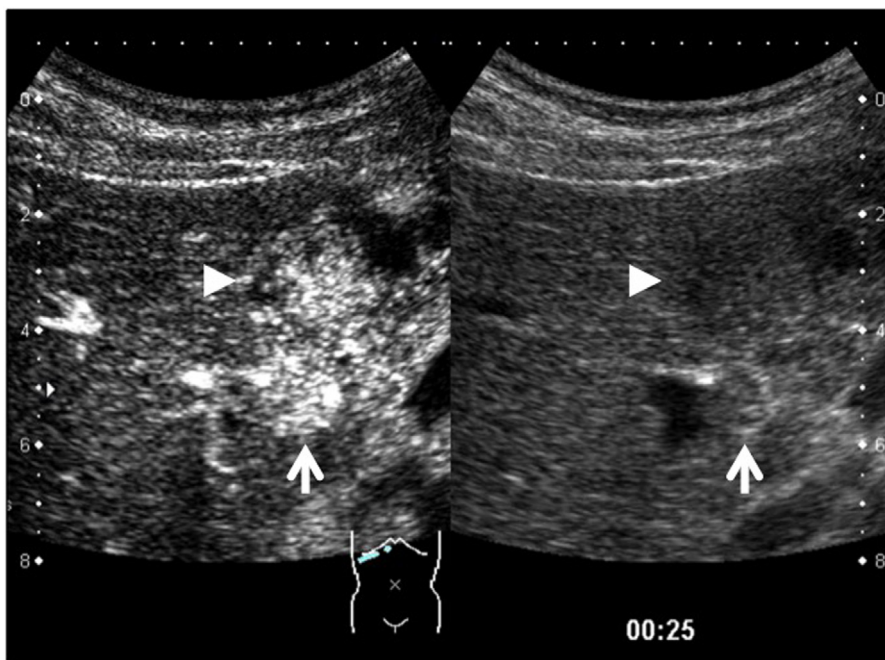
Arterial phase of contrast-enhanced ultrasonography at diagnosis. Main tumor (arrowhead) and suspected portal vein tumor thrombosis (arrow) are well enhanced.
